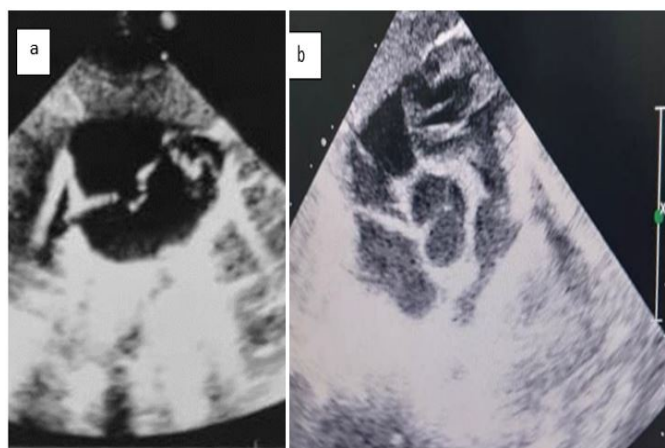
20-Days echocardiogram is showing: a) ASD2 b) moderate to severe MR, MVP, and PPG=45 mmHg.
